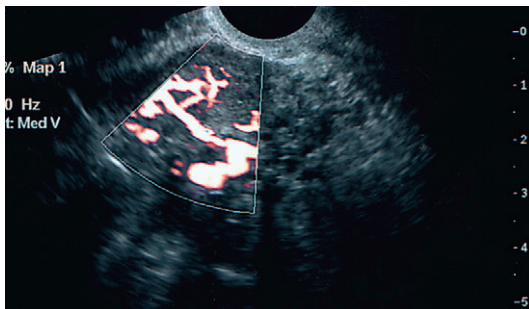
Solid ovarian cancer. Power Doppler demonstrates disordered pattern of flow with irregular branching vessels, anastomoses and a large draining vein.
